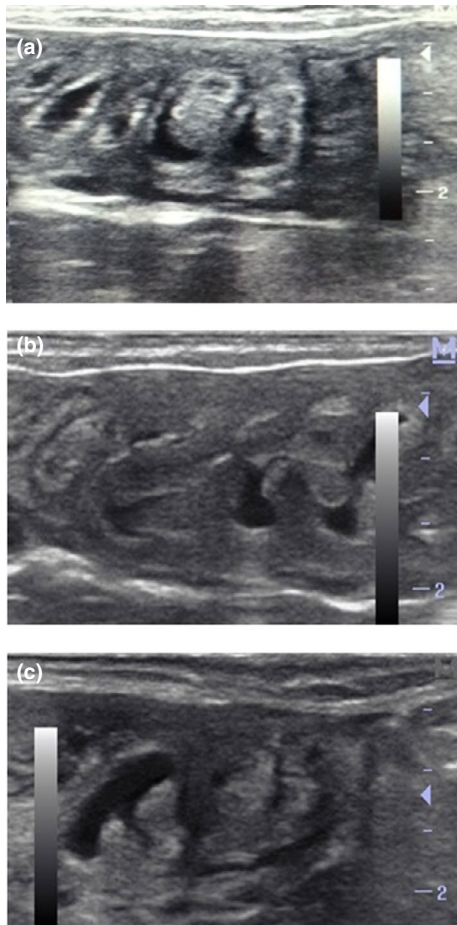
Cervical ultrasonography images according to the classification of degree of cervical misalignment on ultrasonography (DMUS) in Lacaune ewes, (a) DMUS-1: cervix rectilinear, (b) DMUS-2: intermediate, and (c) DMUS-3: highly asymmetrical. Images show longitudinal section of the cervix in the caudal cranial direction (left to right)
